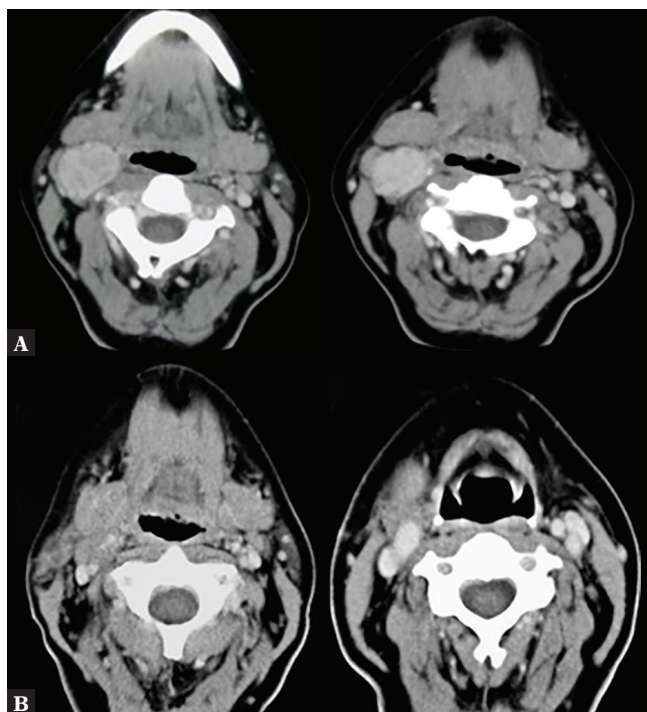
A. CT axial sections after iv enhancement: Nodule with clear distinct borders and homogeneous intake of contrast media in the arterial phase. B. Postoperative image with the lack of residual tissue as well as the lack of pathological enhancement in the area
